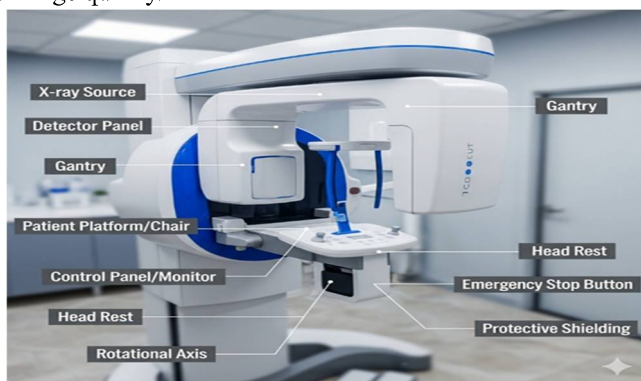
CBCT machine and its parts.
